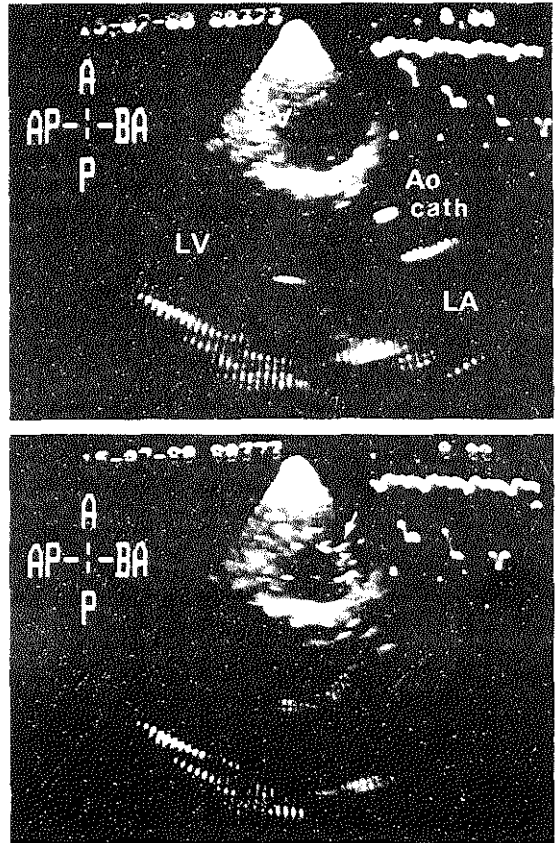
Parasternal long-axis views of a patient with a small ventricular septal defect before (upper panel) and after (lower panel) catheter injection of echo contrast in the left ventricular outflow tract. Echoes appear in the right ventricular outflow tract (arrow) proving the existence of a small left-to-right shunt.
